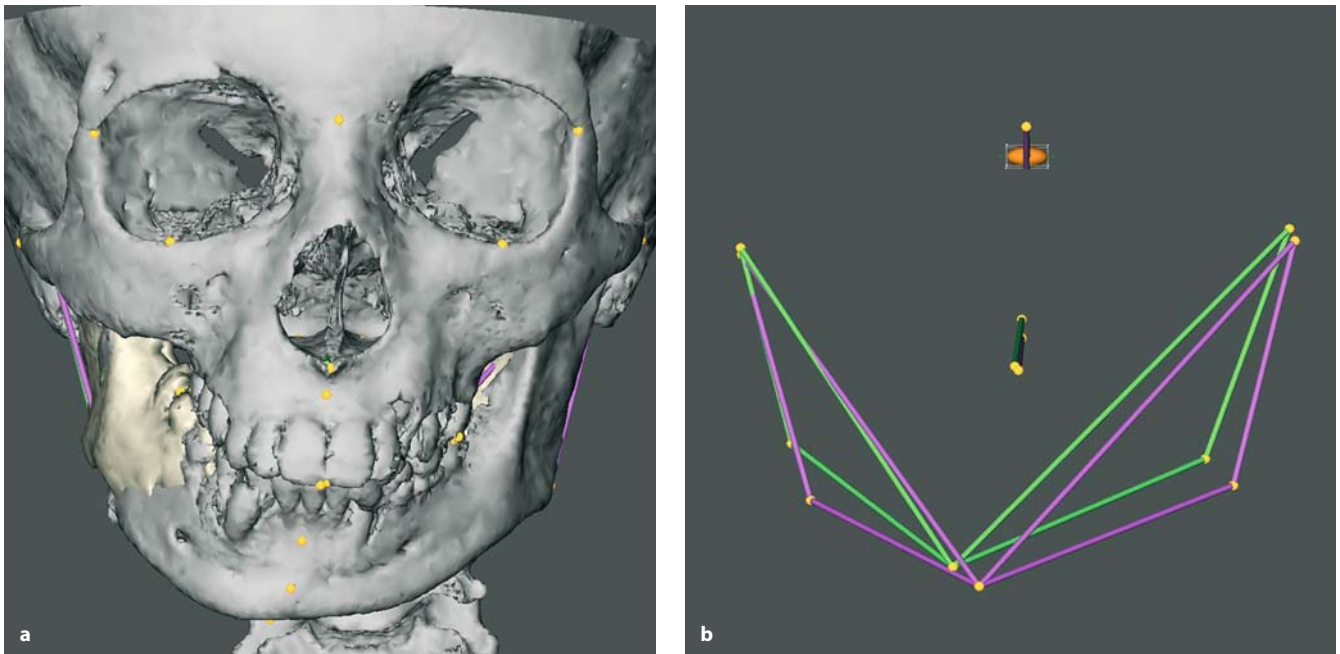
a, b. Superimposition of pre-operative (*green*) and post-distraction (*purple*) 3-D CT hard tissue surface representations and 3-D cephalometric tracings using the 3-D cephalometric reference system. Note the lengthening of the right vertical mandibular ramus and improvement of chin position. Frontal view. (3-D CT, patient B.R.)
